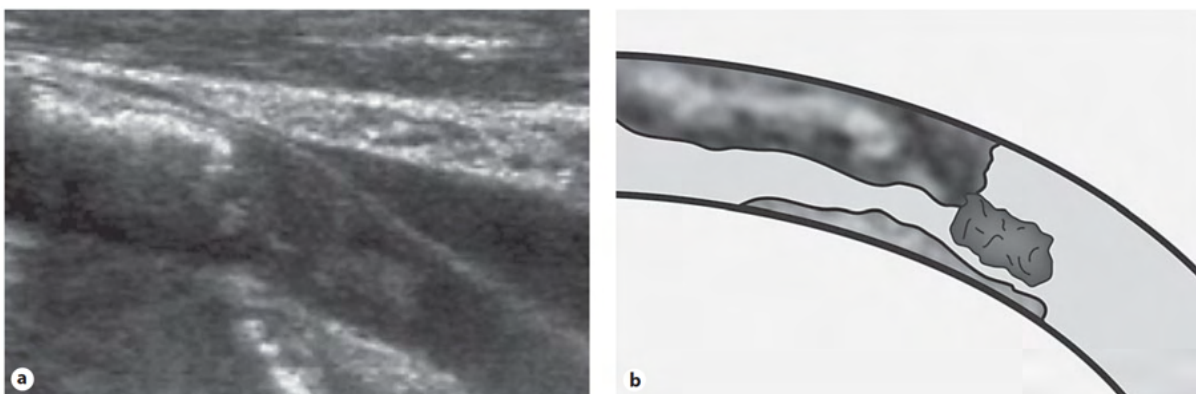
Mobile-thrombus-type seen by supra-aortic trunk ultrasound (A) and its scheme (B) (36).
